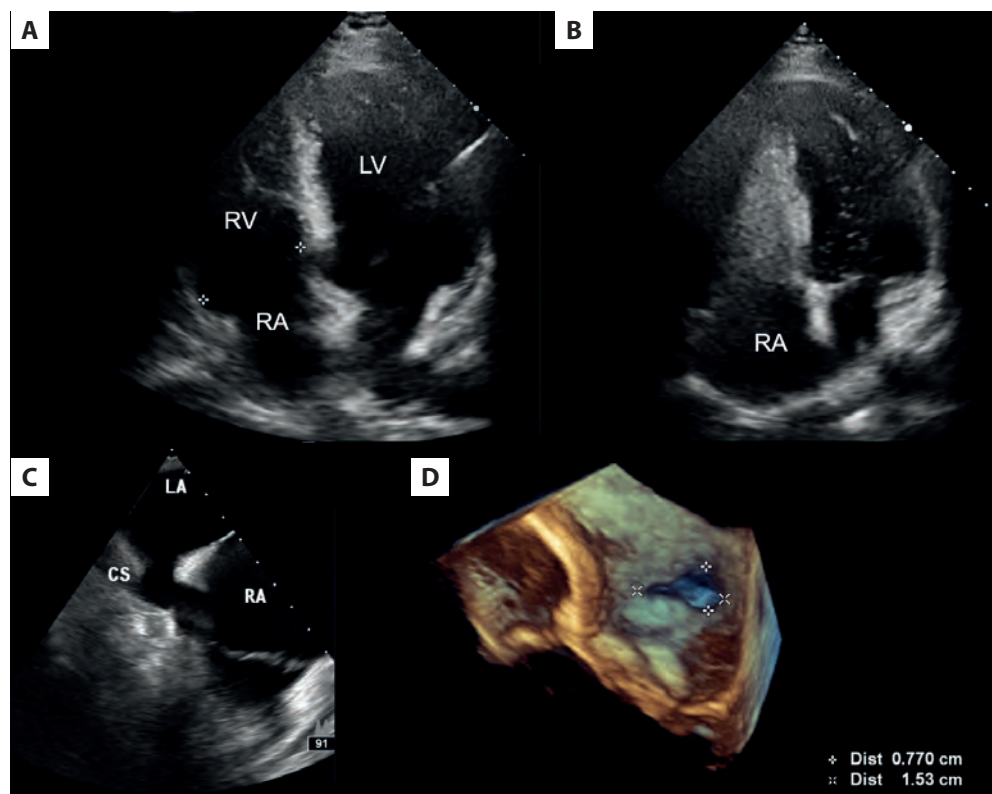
A. Apical four-chamber view demonstrates the mildly dilated right heart chambers. B. Contrast echocardiography from the right antecubital vein showed a right-to-left transition of bubbles in the first three cycles. C. Transesophageal echocardiography revealed a defect between the left atrium and the coronary sinus. D. Three-dimensional echocardiography provided visualization of the pear-shaped defect
